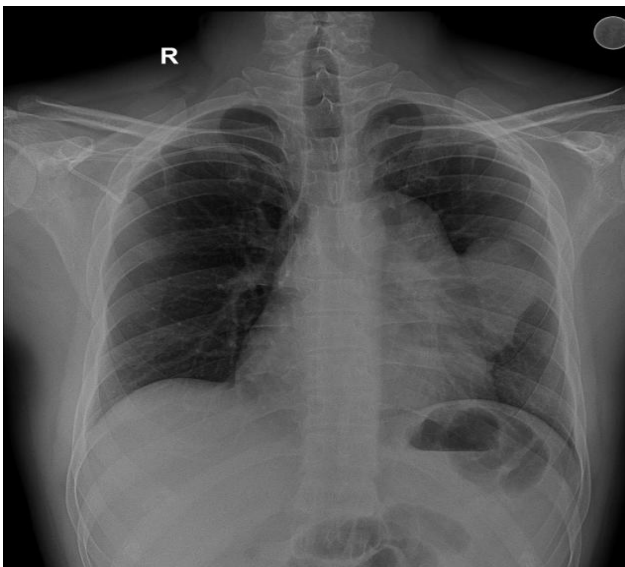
Chest radiograph showing radio opacity in the left mid zone extending from mediastinum, obliterating the left hilar shadow.
